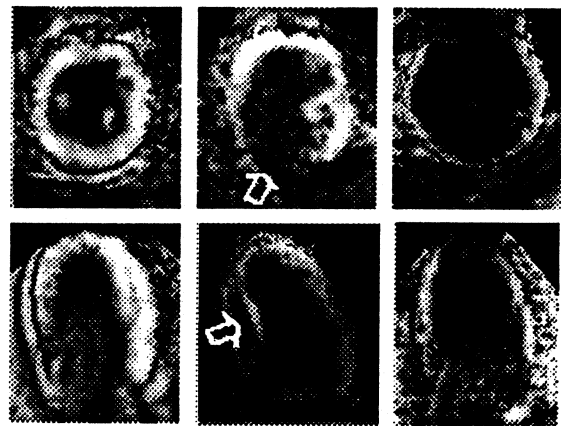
Examples of parametric short-axis (top) and apical 4-chamber (bottom) images obtained in patients: with normal wall motion (left), with regional wall motion abnormalities (center), and with global hypokinesia secondary to dilated cardiomyopathy (right).
